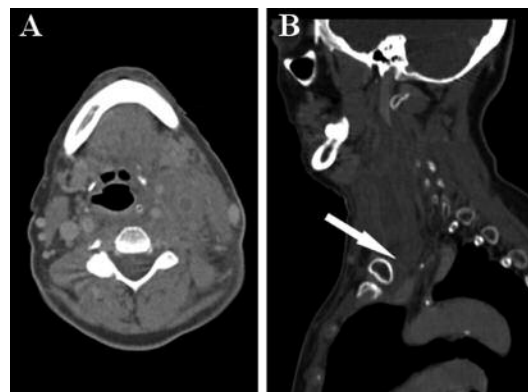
CT-scan of the cervical region showing thrombosis of the internal jugular vein encased within a confluent lymph nodes’ mass (A) and with thrombus extending from below the mastoid process to the jugulo-subclavian venous confluence (B).
